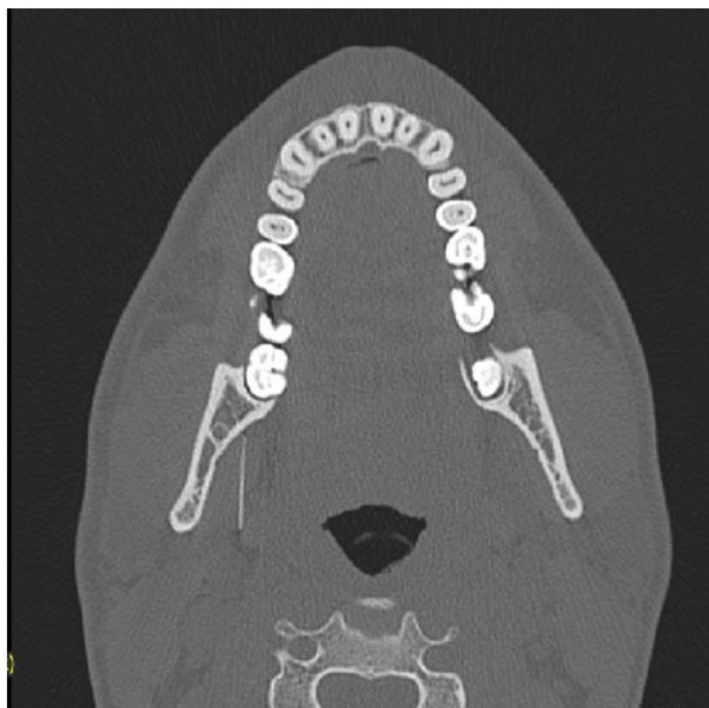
Axial CT-SCAN: the broken needle lies in the right pterygo-mandibular space
